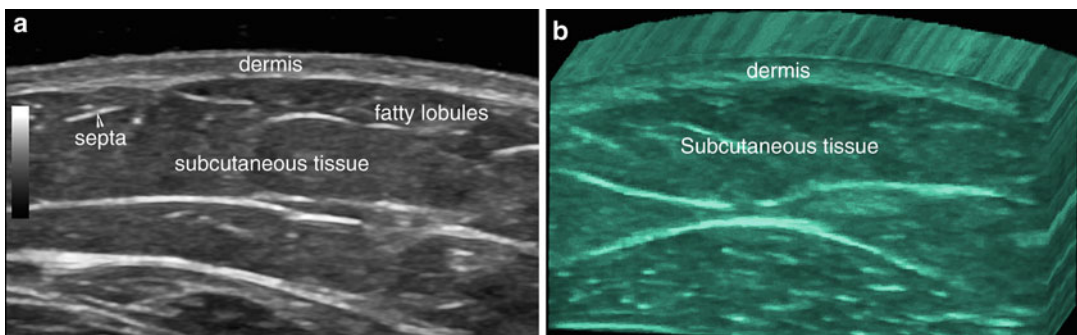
Normal sonographic appearance of the subcutaneous tissue (transverse views). (a) Grayscale ultrasound shows the hypoechoic fatty lobules and the hyperechoic
